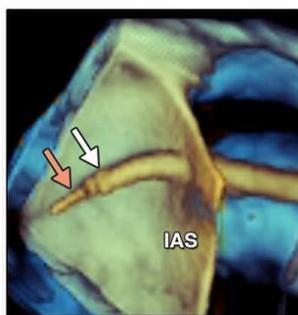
Shows a 3D transesophageal echo (TEE) image during the TS. Color is used to depict depth. Bright orange is closer while darker blue is further away. The transseptal needle is identified by the orange arrow and the sheath is identified by the white arrow.
